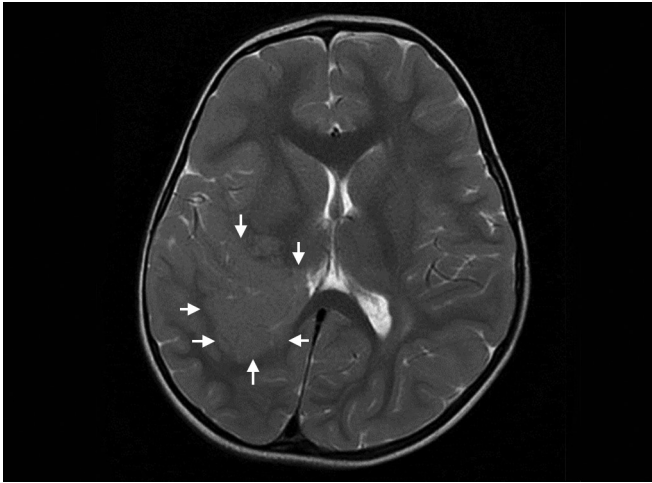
MRI brain of a child with nodular heterotopia. There is large nodular mass of gray matter in the white matter of posterior quadrant of right cerebral hemisphere (arrows). The lesion is extending into the lumen of right occipital horn of lateral ventricle
